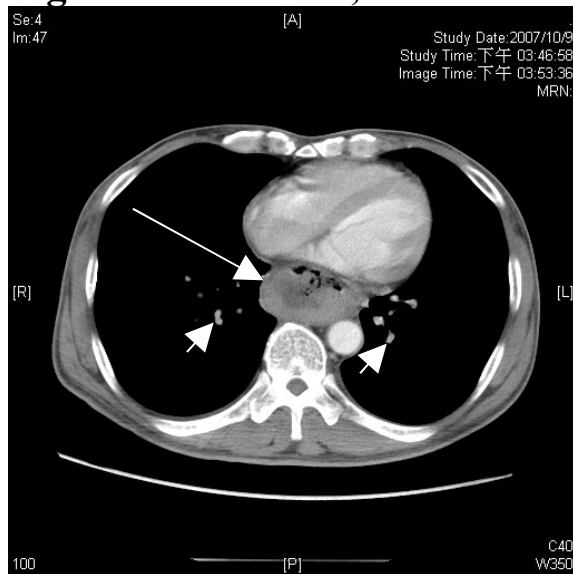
Panel A. Chest CT, Pre-Operation:
